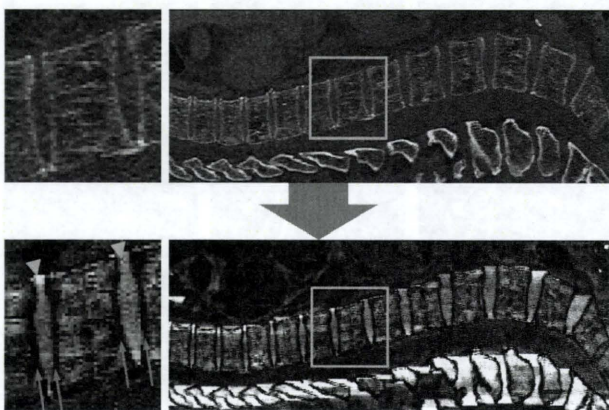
Enhancement of the intervertebral disk based on the bottom-hat filter (above). A sagittal image of the original CT data (case 1; under). The filtered result.
